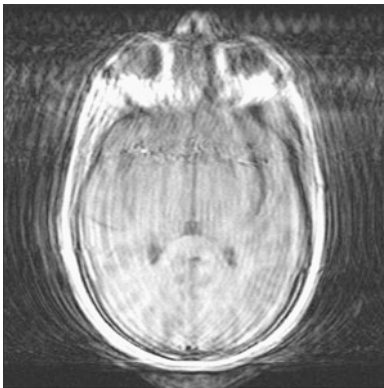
MRI image of the brain. Severe motion artifacts are seen in the horizontal direction of the image
